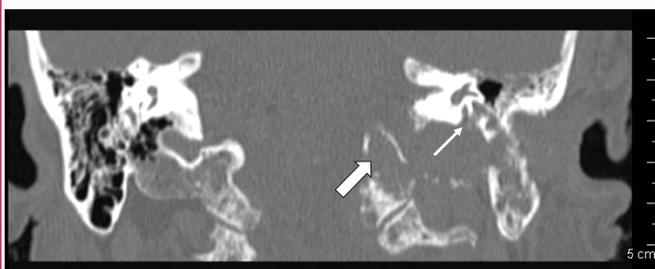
Coronal high-resolution CT scan of the temporal bones demonstrates the involvement of the vertical tract of the left facial nerve canal (arrow) and the erosion of the first left cervical metamers (open arrow).
